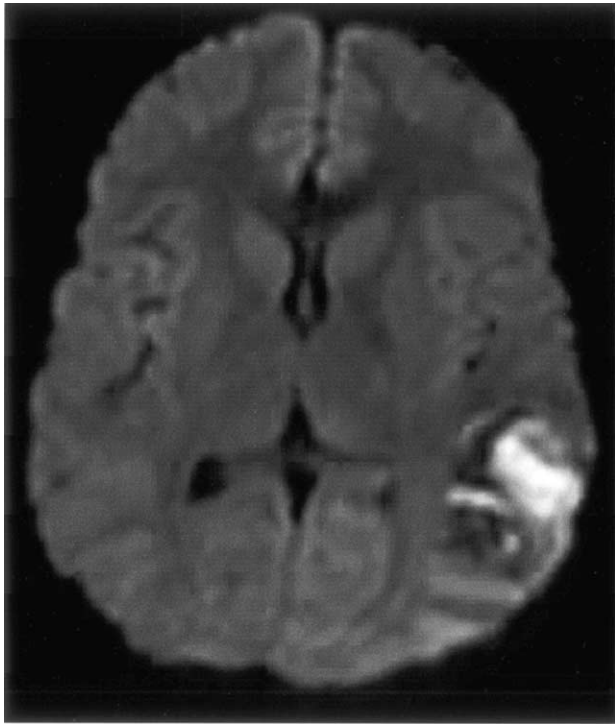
Diffusion-weighted magnetic resonance imaging depicts a hemorrhagic venous infarct in the left cerebral hemisphere.
